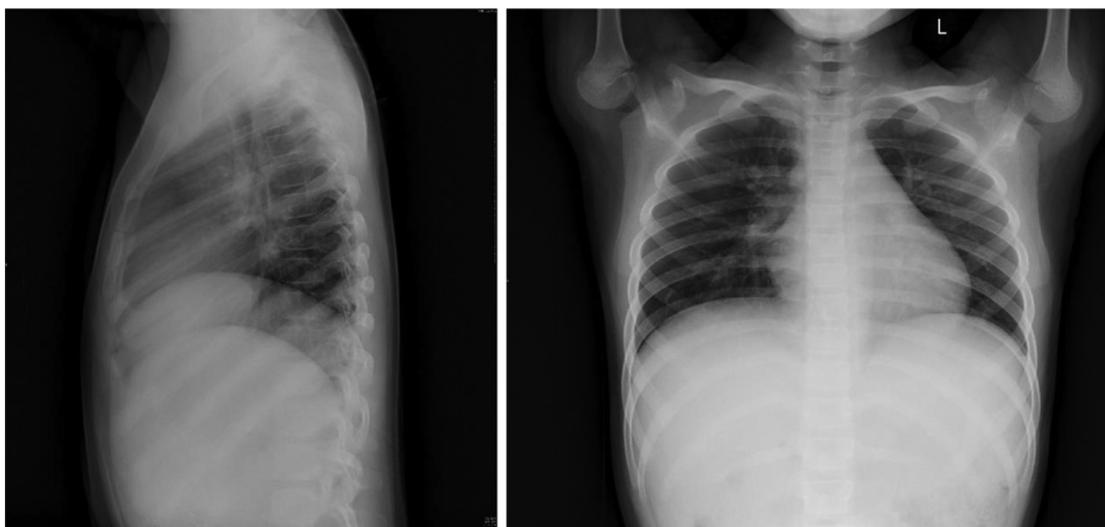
Chest X-ray of the patient demonstrates clear bilateral lung fields, little hilar shadow, and no obvious abnormality of cardiophrenic.
